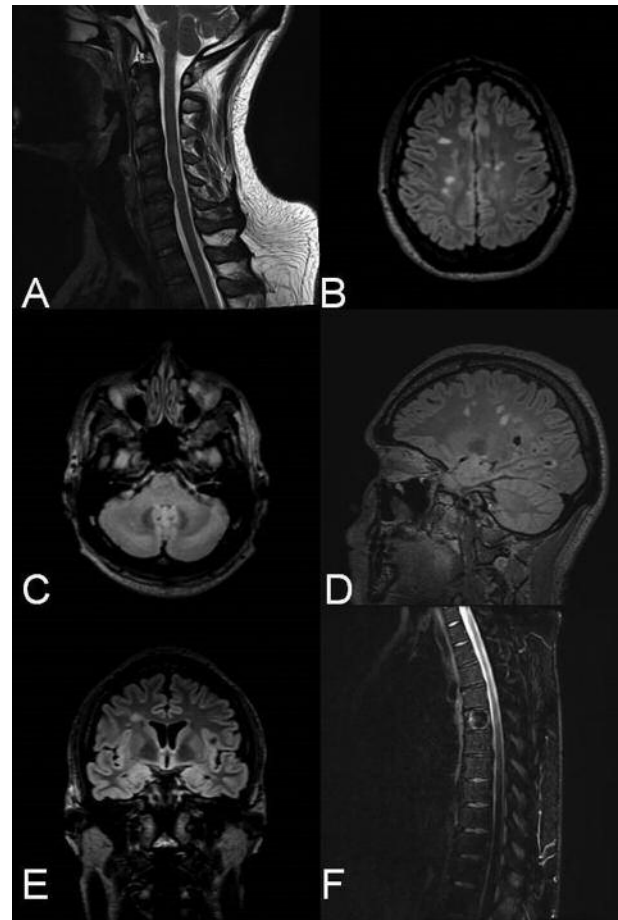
Patient's MRI scans after eight months on ATRIPLA. A. Cervical MRI; Sagittal T2-weighted image reveals hypertensive lesions (C2-C3, C4, C5-C6). B-C. Axial FLAIR (Fluid-attenuated inversion recovery) brain images, with characteristic chronic periventricular and juxtacortical lesions (B), and a cerebellum lesion (C). D. Sagittal FLAIR brain image with hypertensive lesions involving the corpus callosum (Dawson fingers). E. Coronal FLAIR image with right juxtacortical hypertensive lesion. F. Sagittal T2-weighted thoracic MRI, with no apparent intramedullary demyelinating lesions, T5 spinal hemangioma.
